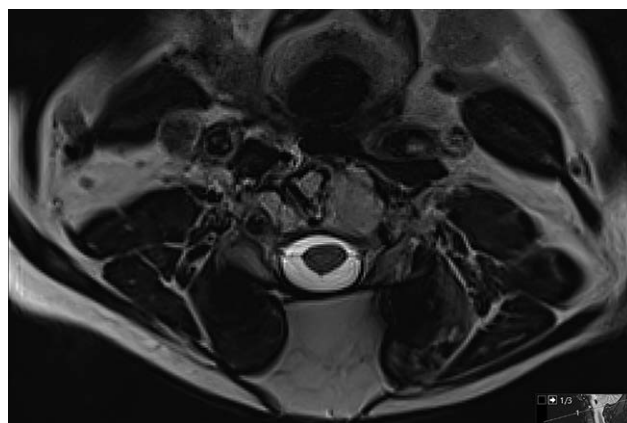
Axial T2-weighted MRI image from patient 13. There are no signs of dead space, and the flap is filling the wound cavity.
